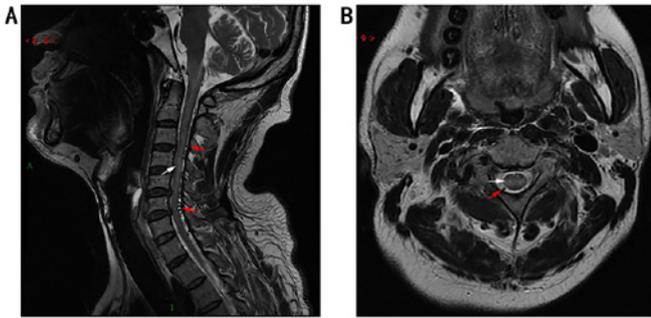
(A) Sagittal and (B) axial T2-weighted magnetic resonance images of abnormal hyperintensity areas in the spinal cord from C1 to C6 (white arrows) and serpentine signal flow voids corresponding enlarged veins dorsal to the spinal cord from C1 to T1 (red arrows).
